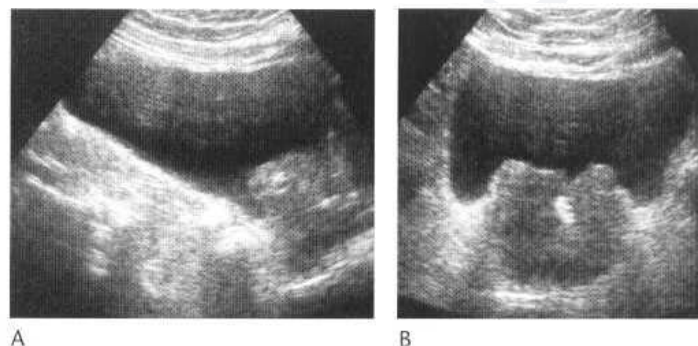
Longitudinal (A) and transverse (B) ultrasound images of the bladder showing moderate lobulated benign prostatic enlargement with areas of calcification.
